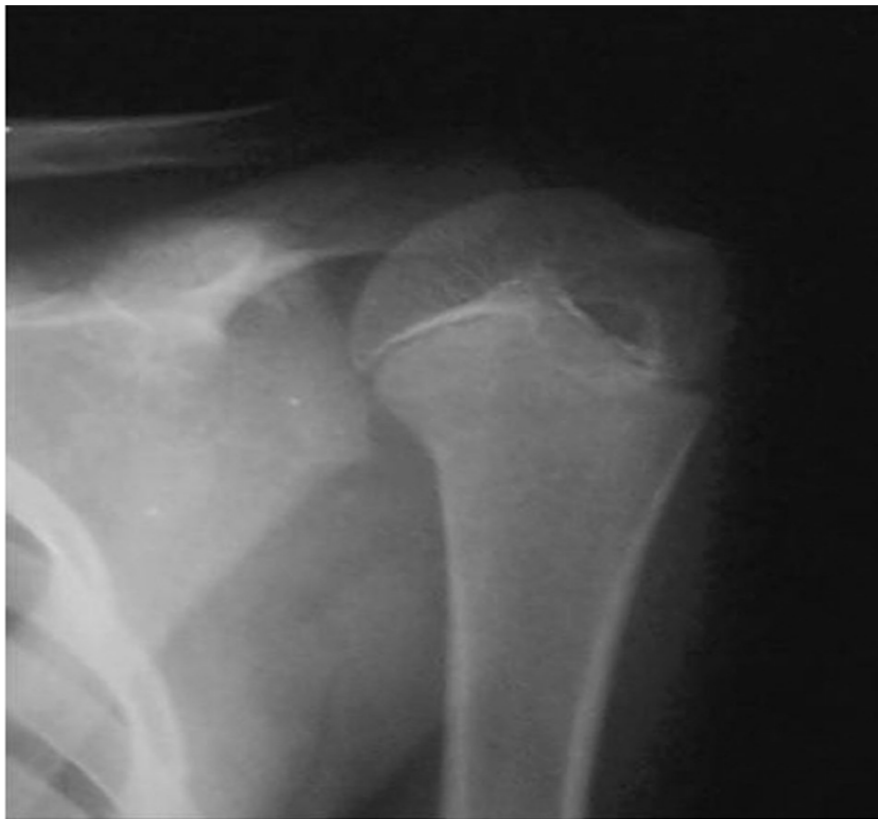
RADIOGRAPH OF A SHOULDER JOINT-9 YRS
